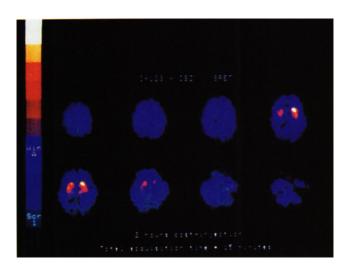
Patient with Parkinson's disease. A dynamic SPECT dataset demonstrates the temporal changes of the distribution of $[^{123}I]$ IBZM in the brain.
